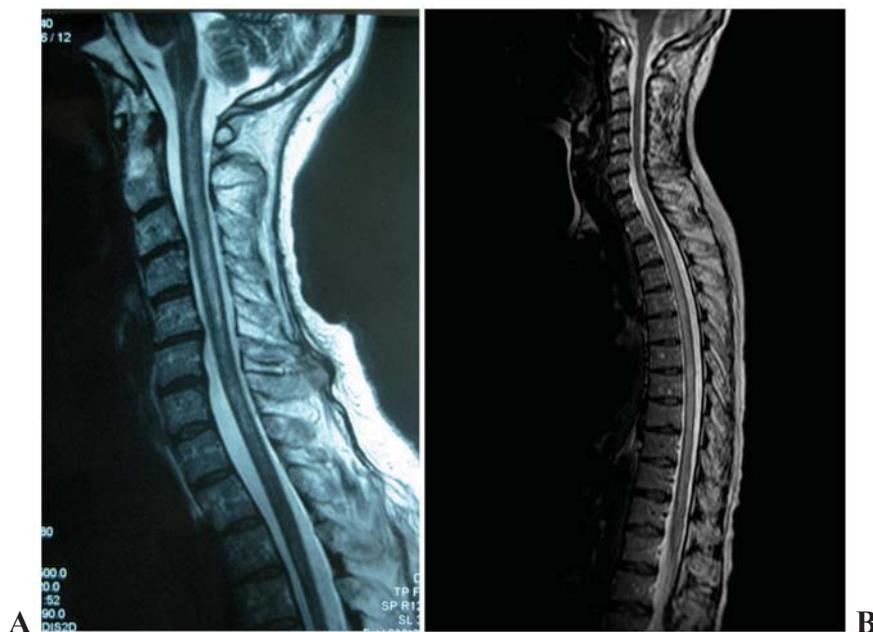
Magnetic resonance (MR) T2-weighted sagittal image from 2009.
